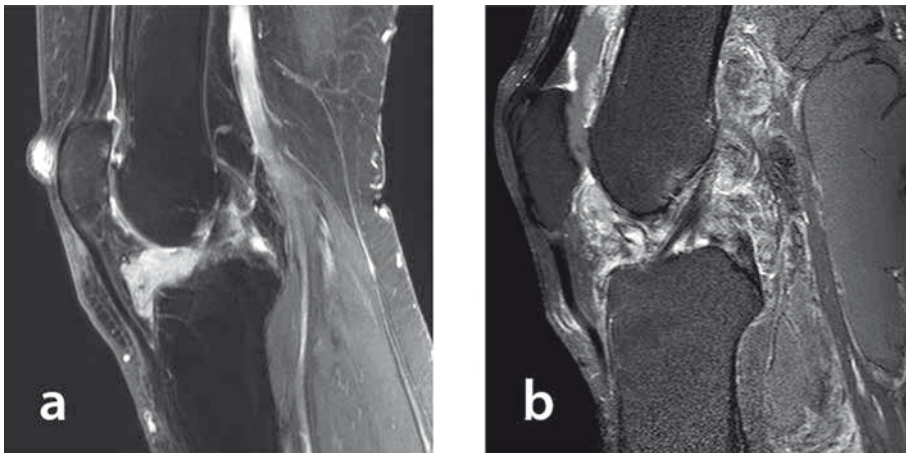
Localized- and diffuse-TGCT sagittal T1-weighted MR image after intravenous contrast injection with fat suppression. Tumour region enhances by contrast injection. a. A localized-TGCT involving Hoffa's fat pad in the anterior part of the left knee in a 55-year-old female patient (L4835). b. Left knee in a 61-year-old male patient with extensive recurrent diffuse-TGCT located intra- and extra-articular with an additional posterior large Baker's cyst including tumour (L3496).
